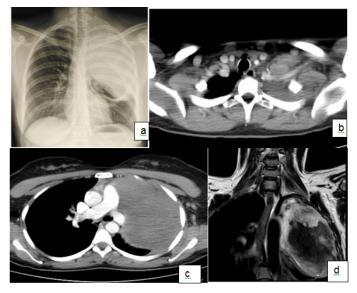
(a) Chest X ray demonstrated a large apical opacity extending to the left chest. (b and c) Chest CT scan showed the mass in the region of the left apex surrounding the subclavian vessels and protruding on the left pleural cavity compressing the left lung. (d) At MRI the subclavian artery was compressed by the mass and the brachial plexus was not infiltrated.
